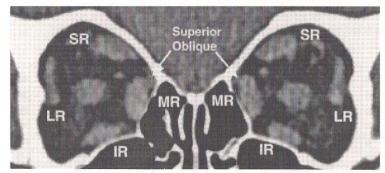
CT scan of 6 year old girl with "A" pattern esotropia 60Δ greater in elevation than depression. Note LR displaced superiorly and SR displaced nasally in both eyes.
